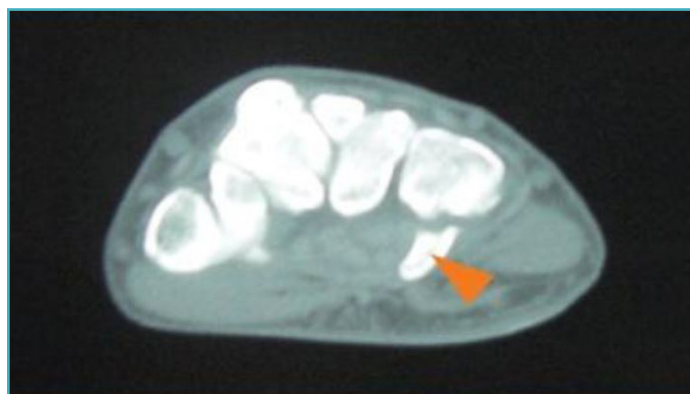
CT scan showing fracture of hook of hamate at its base.
